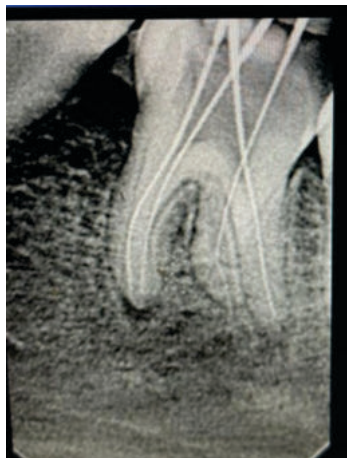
Radiograph Of K-files In The Canals And An Additional Root RE Seen
